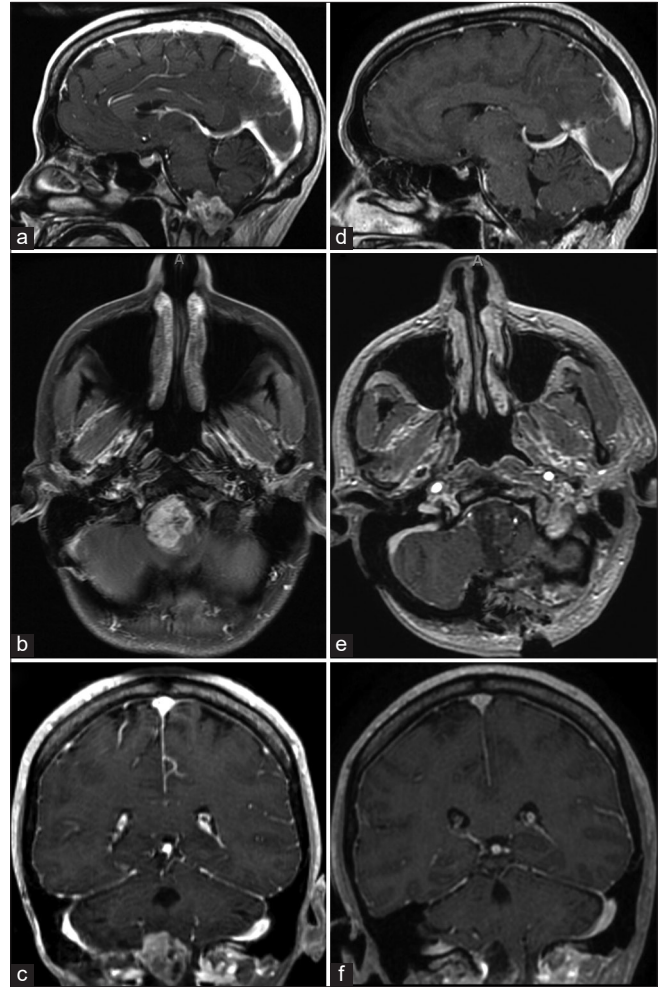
MRI of astroblastoma MN1-altered tumor. (a-c) Sagittal, axial, and coronal preoperative T1 MRI revealing an intra-axial, heterogeneously enhancing lesion centered in the cervicomedullary junction with rostral extension into the pontomedullary junction and caudal extension into the C1-C2 spinal cord. (d-f) Sagittal, axial, and coronal postoperative T1 MRI demonstrating successful resection of the lesion.
